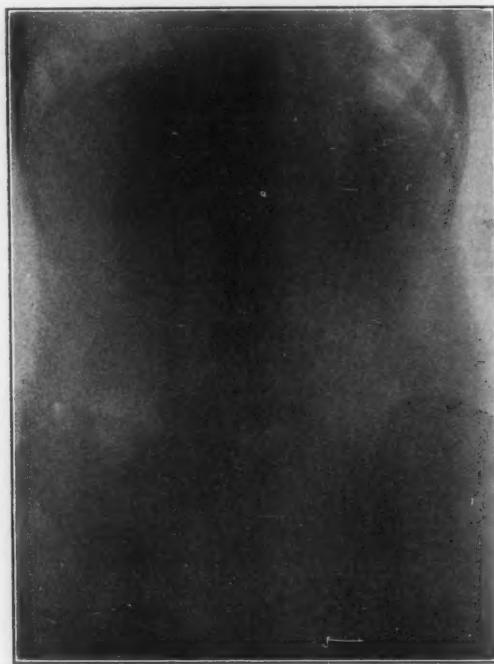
Radiograph by Dr. L. G. Cole, showing tacks in the intestines in progress of passing through. Tacks were swallowed by the patient in attempt to aspirate them.
